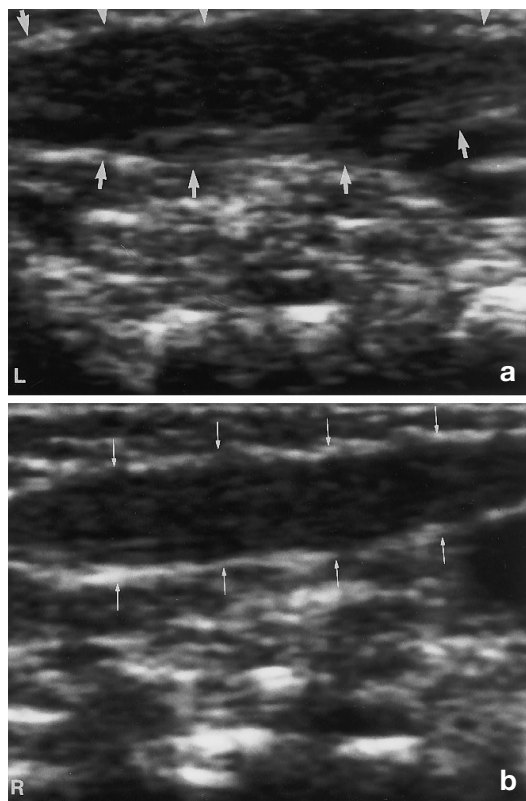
Ultrasound of the right (*R*) and left (*L*) neck in longitudinal view shows fusiform enlargement of the left sternocleidomastoid muscle (*short thick arrows*) compared to the right side (*long thin arrows*). The echogenicity of the left sternocleidomastoid muscle is similar to the right side and is homogeneous. The borders are well defined. On transverse views (*not shown*), there was no associated significant mass effect on adjacent vessels or trachea
